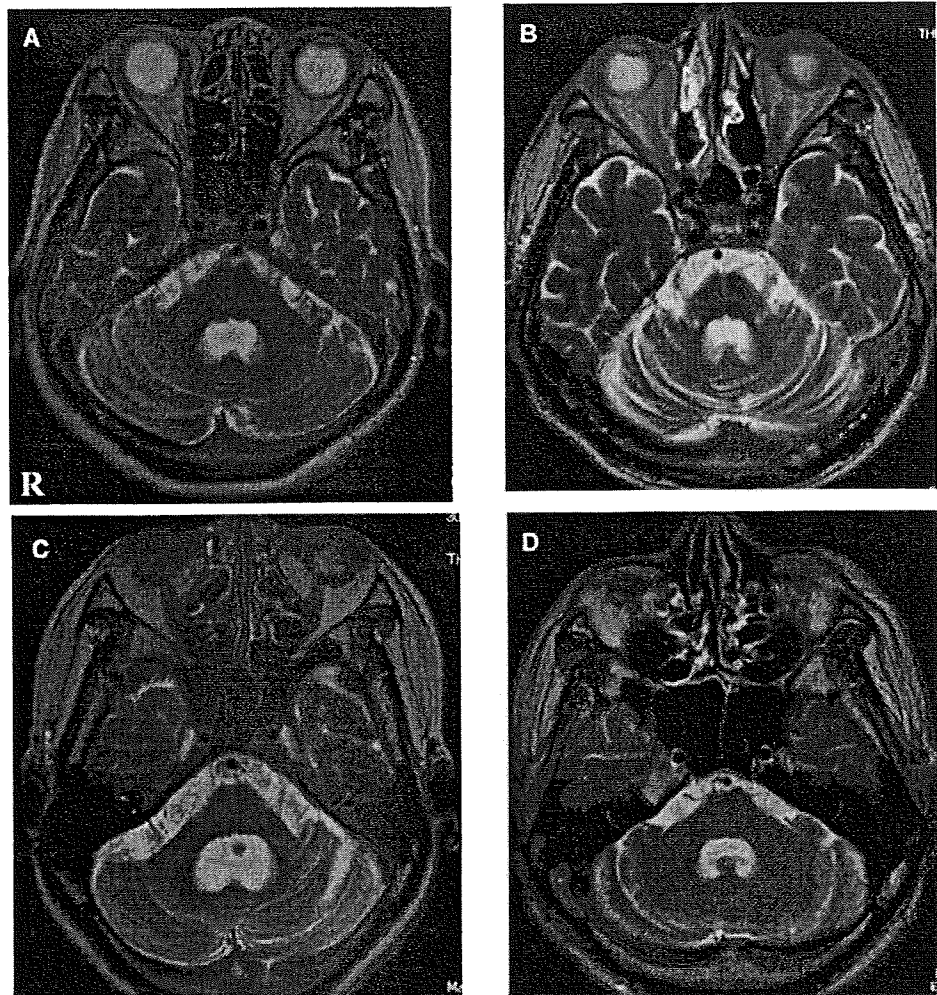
T2-weighted MR images (axial images) in patients with MSA-C. The various degrees of brain atrophy were observed in the cerebellum, pons, and middle cerebellar peduncles. Cerebellar atrophy with brainstem involvement was mild in patients 1 (A) and 7 (D), moderate in patient 4 (C), and severe in patient 2 (B). Abnormal signal hyperintensity in the pontine base was clearly observed in patient 2 (B).
